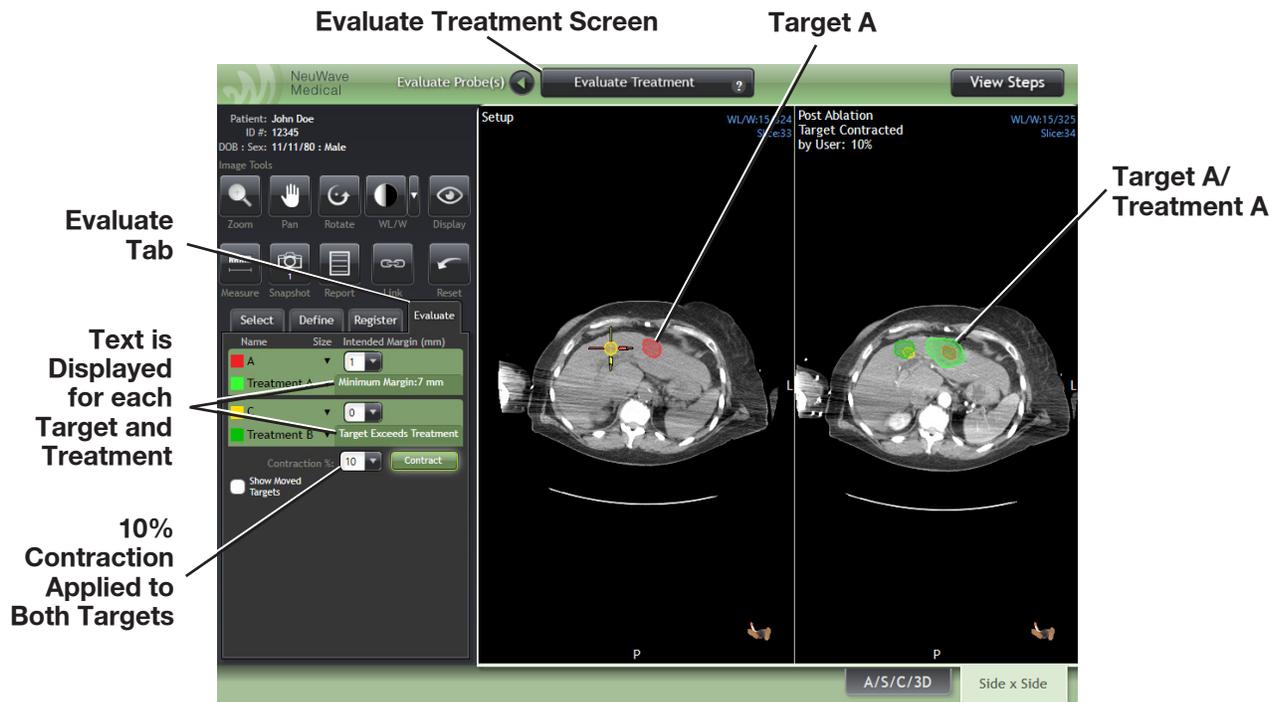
Side x Side Axial View comparison of the Setup CT Series (10% contraction not applied) and the Post-Ablation CT Series (10% contraction applied)
